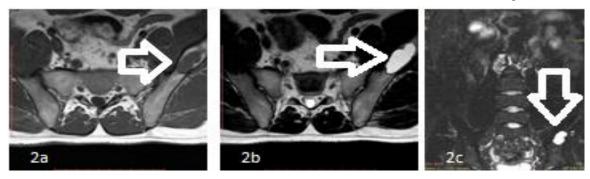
Non contrast magnetic resonance images. (a) T1W axial section shows a well defined hypointense lesion with mild expansion in the left iliac bone with slightly marrow changes in the peripheral region (white horizontal arrow). (b) T2W axial section shows the said lesion as hyperintense with well defined margins (white arrow). (c) STIR coronal image shows the lesion as still hyperintense without any surrounding edema (white downwards arrow).
